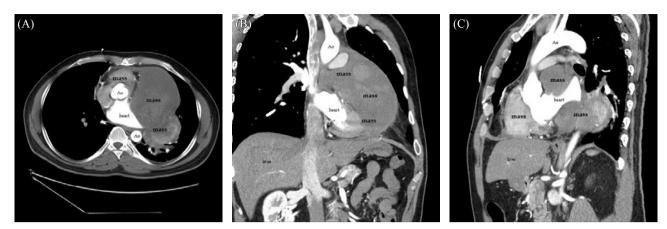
The post-contrast CT (A, B, C) revealed a huge heterogeneous mass with hematoma formation; the ventricles were compressed by tumor. Ao: aorta
